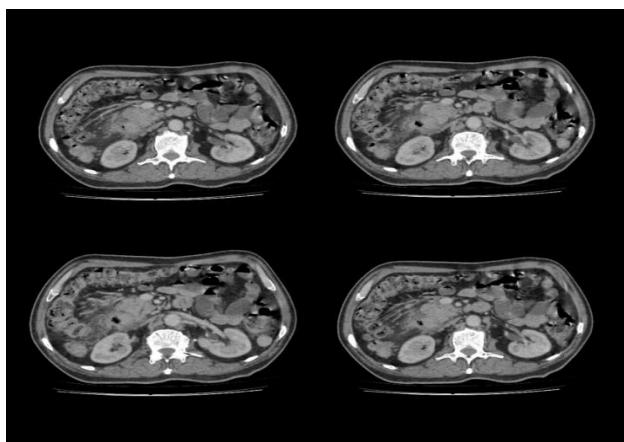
Axial venous phase CT.
